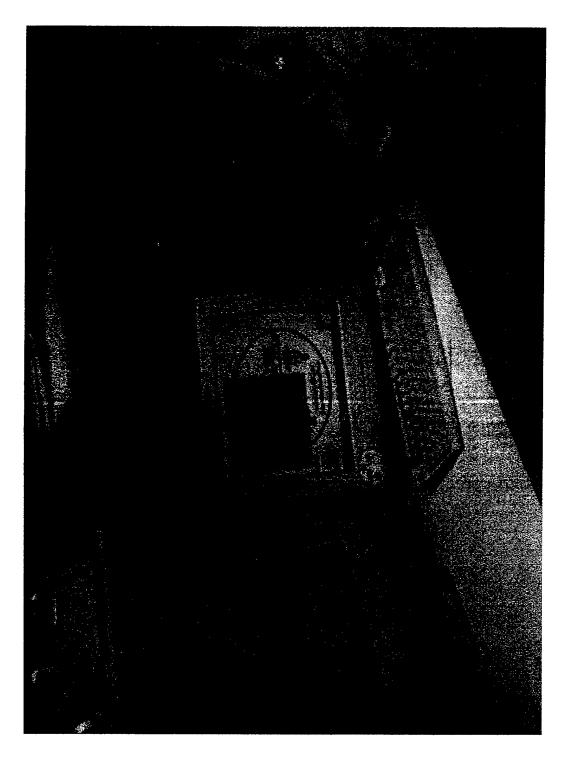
BAMC Cardiology Staff Seated At BAMC LifeLink<sup>TM</sup> Terminal during Remote Echocardiography Demonstration
